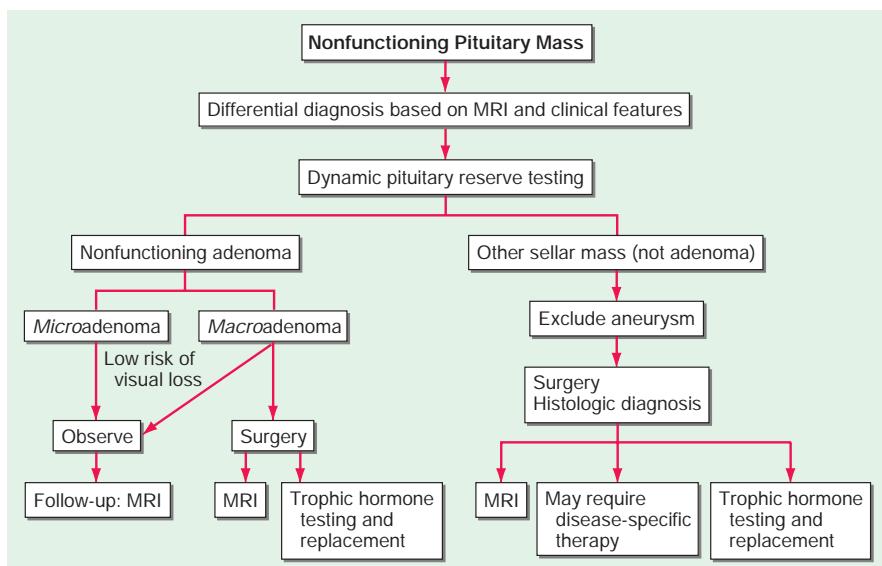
Management of a nonfunctioning pituitary mass. MRI, magnetic resonance imaging.
